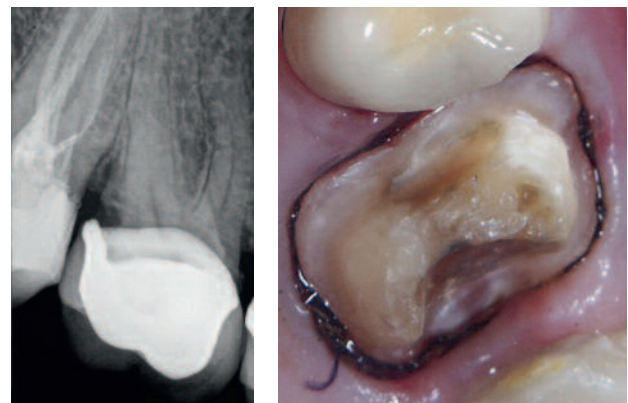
Preoperative radiograph showing recurrent caries at the distal margin of existing crown on tooth # 16
